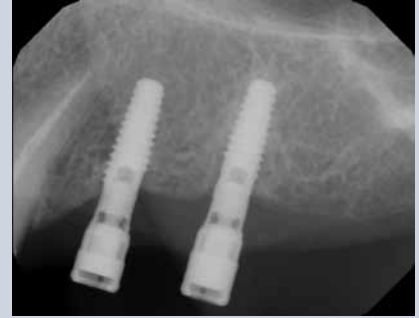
Six month post-operative radiograph demonstrating a combination of crestal bone loss and regeneration of the apical component of the defect. Crestal bone loss is more common when lacking good regeneration conditions.
